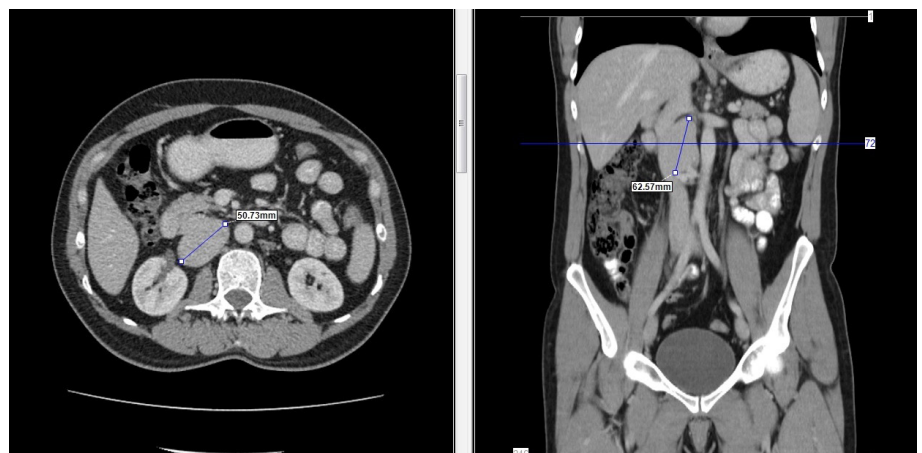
Vertical and sagittal section of computed tomography images
